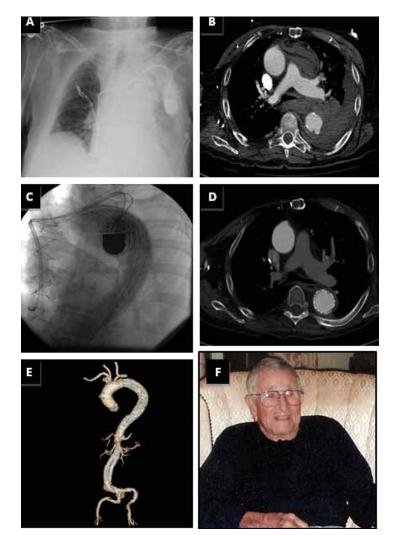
Preoperative, postoperative, and follow-up images of rTAA and rAAA in the same patient. (A) Chest X-ray on presentation demonstrating left hemothorax. (B) CT showing rTAA with hemothorax. (C) Deployment of a TAG[®] endograft (W.L. Gore & Associates, Inc., Flagstaff, AZ) for repair of ruptured aneurysm. (D) CT at 2 years follow-up. (E) 3D reconstruction of thoracic and abdominal aortic stent graft repair of rTAA and rAAA. (F) Patient with full recovery 2 years after eEVAR of combined rTAA and rAAA.
